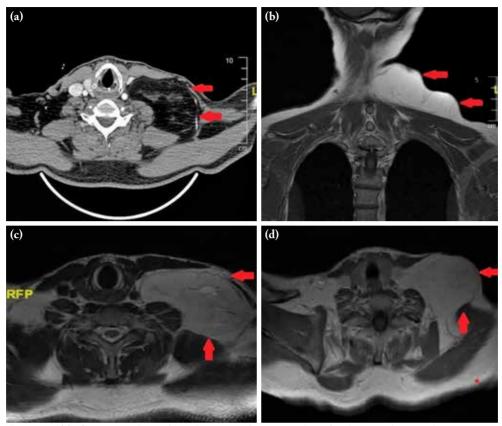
(a) Contrast enhanced axial computed tomography of a lipoma showing homogeneous and hypodense lesion with no contrast enhancement; (b) Coronal T₁-weighted magnetic resonance imaging of a lipoma showing hyperintensity similar to subcutaneous fat signal; (c) Axial T₂-weighted magnetic resonance imaging of a lipoma; (d) Well-circumscribed, encapsulated and fat-containing lesion with no contrast enhancement in axial magnetic resonance imaging with contrast (red arrows show lesion in figures).
